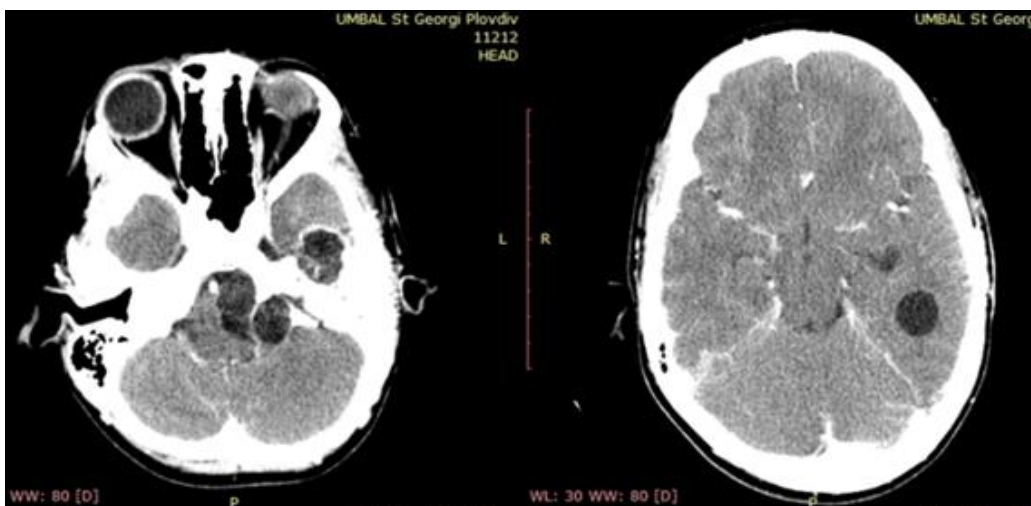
CT image of multiple supra-infratentorial hydatid cysts
